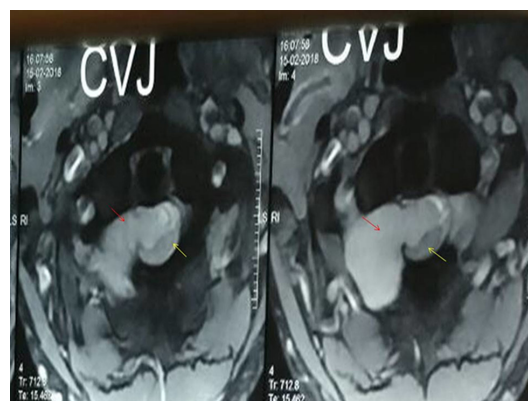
MRI T2-weighted axial view showing 'dumbbell shaped' lesion (red arrow) compressing the upper cervical cord (yellow arrow) at the craniovertebral junction.
